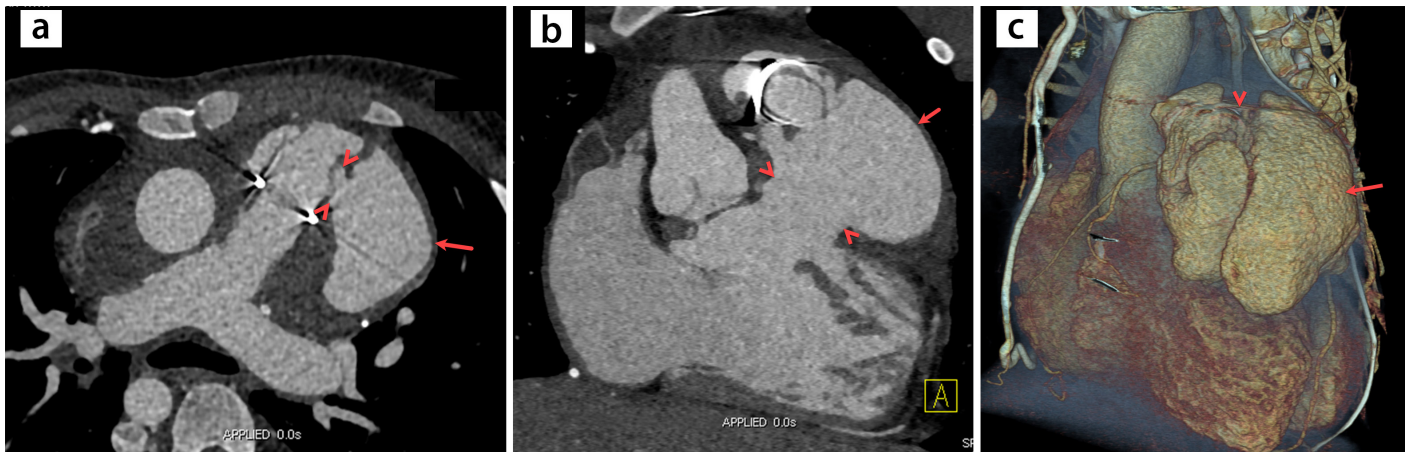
(a-c) A 15-year-old boy with a history of pulmonary valve replacement for tetralogy of Fallot underwent cardiac computed tomography (CT) angiography with a suspected right ventricle outflow tract pseudoaneurysm. (a) Axial and (b) coronal CT images revealing a giant multiloculated pseudoaneurysm (arrows) with a narrow neck (arrowheads). (c) Three-dimensional volume rendering CT image demonstrating a right ventricular pseudoaneurysm (arrow) with a narrow neck (arrowhead).
